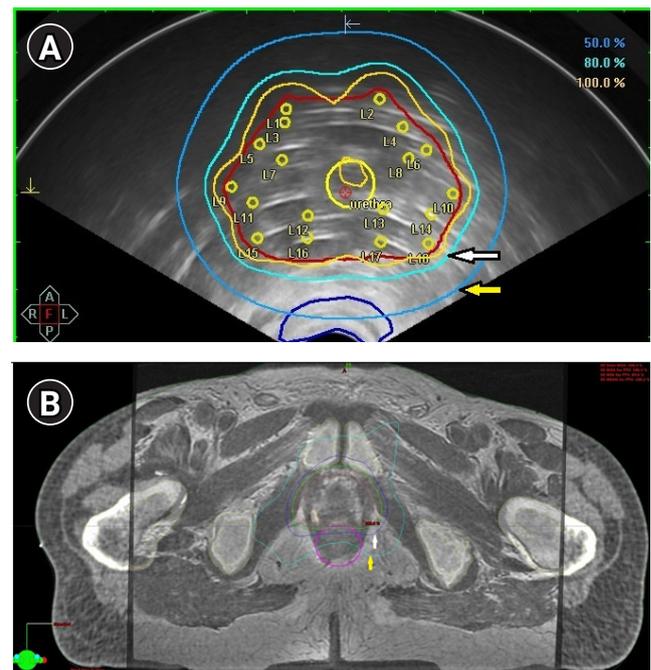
Axial views of the US-based trans-rectal HDRBT and SBRT plans with overlaid dose distribution. (A) Axial view of the US-based HDRB plan. Red line indicates contour of prostate; dark blue line, contour of anterior rectal wall; yellow line, 100% isodose; light cyan line, 80% isodose (white arrow); dark cyan line, 50% isodose (yellow arrow). Only 50% isodose cross small volume of anterior rectal wall. (B) Axial CT-MRI fused image of the prostate with one visualized fiducial in the right lobe. Treatment plan of the prostate SBRT. Red line indicates prostate and CTV contours; magenta line, contour of the rectum; green line, 100% isodose; dark blue line, 80% isodose (white arrow); cyan line, 50% isodose (yellow arrow). Half of the rectum volume is covered by 50% isodose, the whole anterior rectum wall is covered by 80% isodose, 100% isodose “touch” anterior rectal wall. SBRT, stereotactic body radiotherapy; HDRB, high dose rate brachytherapy; US, ultrasound; CT, computerized tomography; MRI, magnetic resonance tomography.
